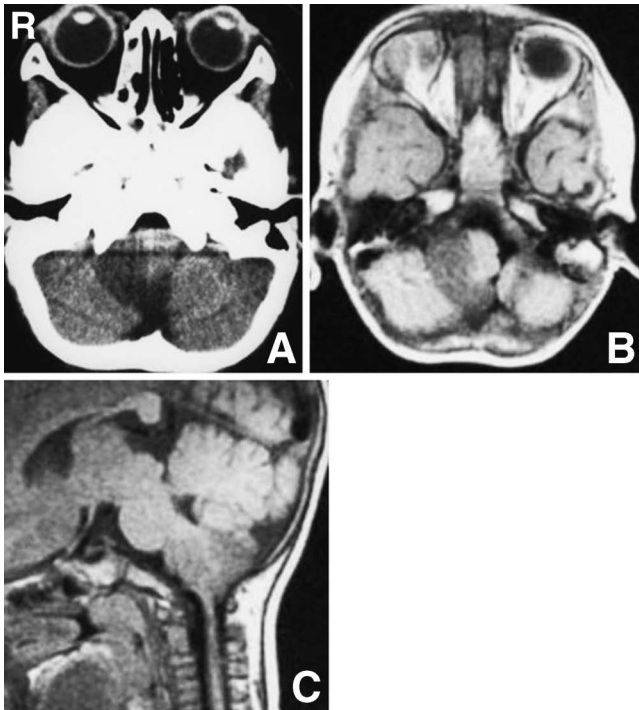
Neuroimaging findings at age one year. A: Axial computed tomography scan showing a tumor mass with a cystic component at the posterior fossa as low density. B: Axial T₁-weighted magnetic resonance image showing the tumor as low intensity. C: Sagittal T₁-weighted magnetic resonance image showing a cystic component at the posterior fossa.
